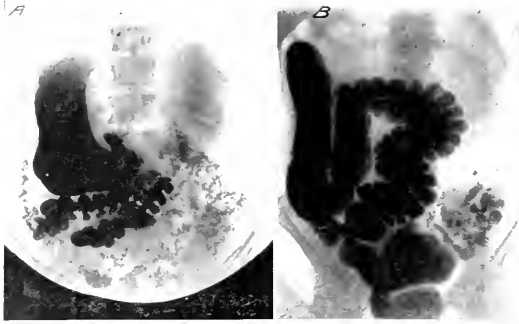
A*. Immediate and twelve hour roentgenogram of fourth case of non-fused, non-rotated cecum with deficient migration. (Plate taken with patient in erect position.) *B*. Barium enema plate of same case. (Plate taken in prone position.)
